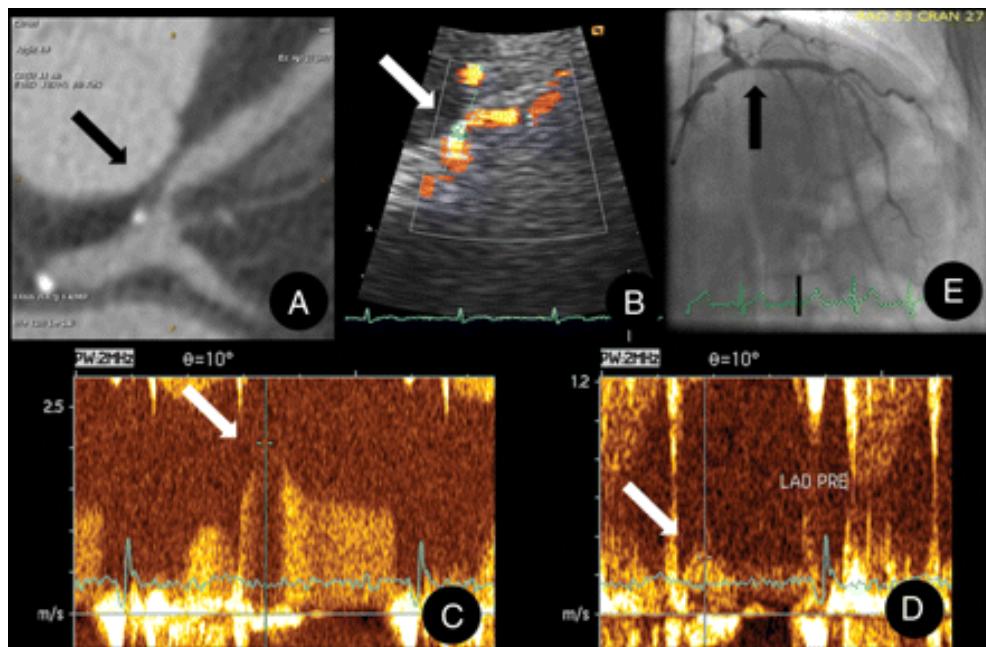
Analysis of coronary stenosis by sequential computed tomography angiography and transthoracic Doppler echocardiography.
